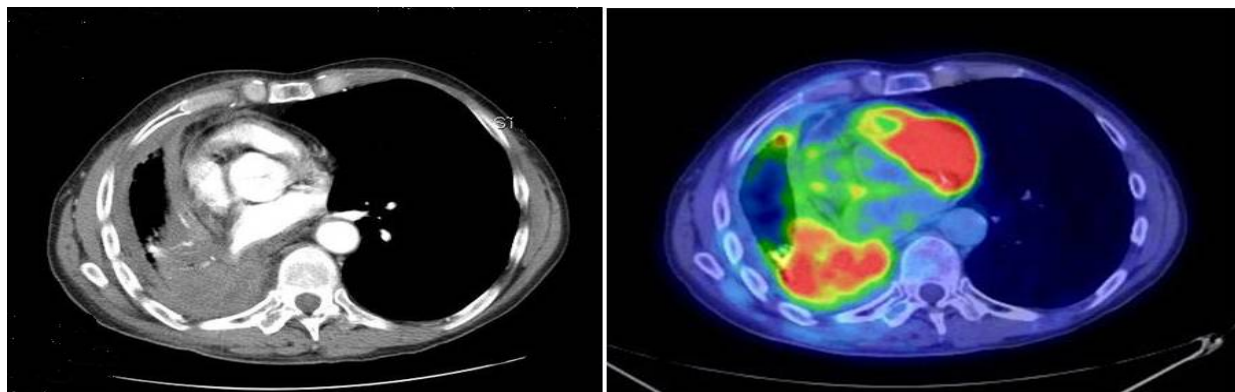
a CT image of lung cancer
